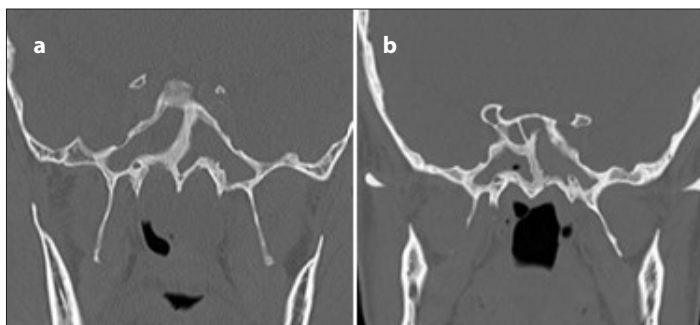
a, b. Axial (a) and coronal (b) CT images show that in both patients with CRS with nasal polyp, osteitic change is observed in the sphenoid sinus walls.
